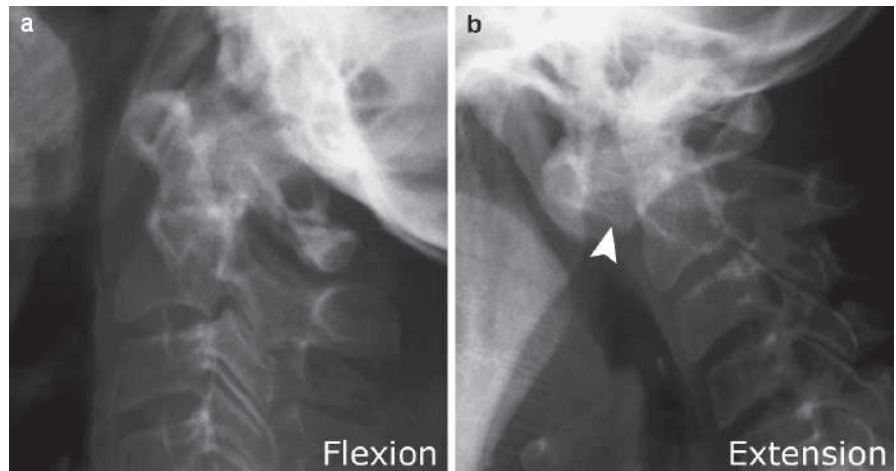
Lateral plain radiograph of the atlantoaxial joint of a patient with atlantoaxial subluxation due to RA shows a significant gap between the anterior arch of the atlas and the odontoid process (*arrowhead*) on extension radiograph
